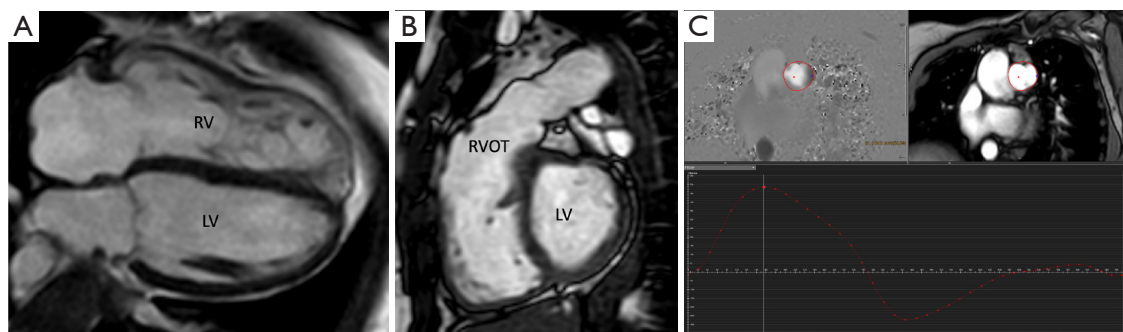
A 45-year-old woman with repaired tetralogy of Fallot with a transannular patch where echocardiography exhibit dilated RV and severe pulmonary regurgitation. Standard CMR protocol to evaluate RV volume and function, and flow measurements. (A) 1.5 T CMR, 2D bSSFP image in a 4-chamber view with dilated trabeculated RV as compared to the LV. (B) 2D bSSFP in an oblique view over the RVOT revealing slightly dilated and irregular borders of the pulmonary artery. (C) 2D phase contrast flow measurement traced above the pulmonary valve in the phase image (upper left) and the anatomic image (upper right) with flow curve (below) and a regurgitant fraction calculated to 40%. RV, right ventricle; LV, left ventricle; RVOT, right ventricular outflow tract; CMR, cardiovascular magnetic resonance; 2D, 2-dimensional; bSSFP, balanced steady state free precession.
